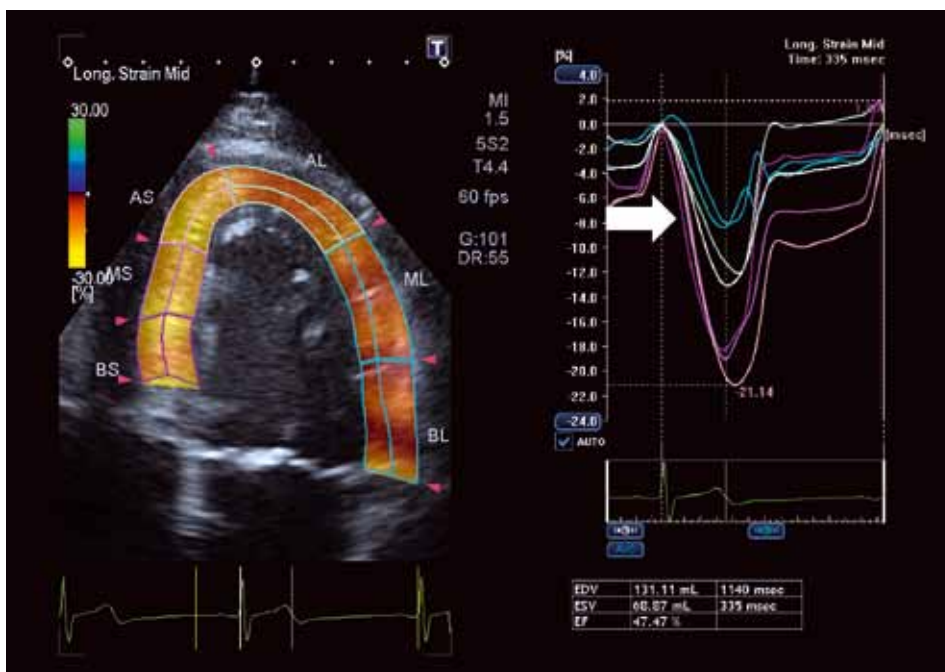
The automatic strain analysis from an apical four-chamber view in a NSTEMI patient with occluded circumflex (Cx) artery shows reduced colour-coded strain values in the segments supplied by the Cx artery (left). Colour-coding from yellow to green indicates strain from +30% to -30%. Yellow/orange indicates preserved strain. Brown indicates areas with reduced strain. Strain curves for the six LV segments are displayed on the right. The curves representing the segments supplied by the Cx artery show reduced strain values of -8% (white arrow).
